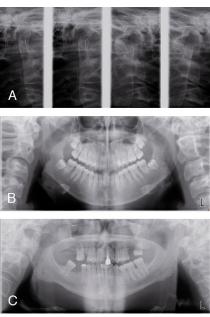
A–C, Preoperative conventional radiographic examinations showing 3 cases of highly located condylar head fractures.
